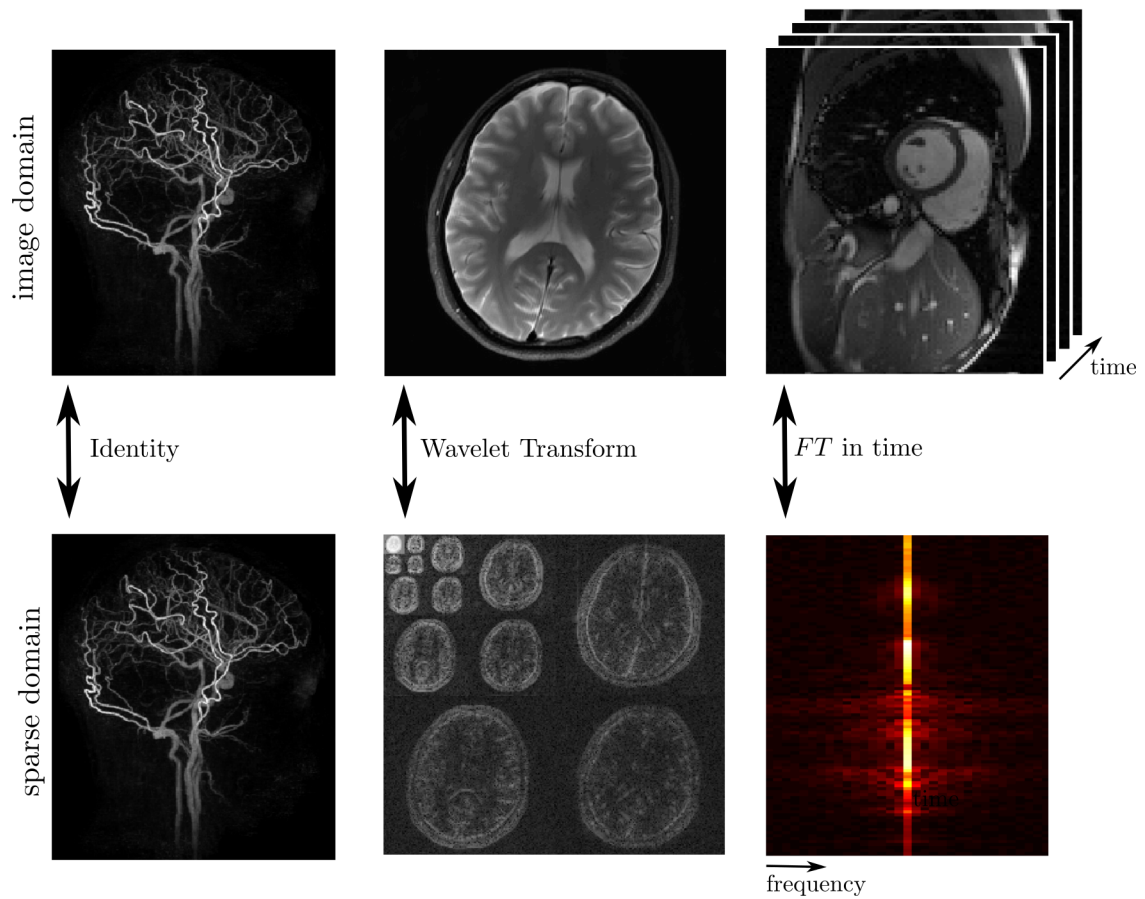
shows three different examples of sparsity that have been used to perform CS reconstructions in MRI. The most prominent example is angiography (shown on the left), where MRI is used to depict blood vessels. Angiograms exhibit a high level of sparsity directly in image space, which make them an ideal candidate for CS reconstructions. Other data (such as the brain image shown in the middle) are not sparse in image space, as can easily be appreciated. An important sparsifying operation is the Wavelet-Transform, which can also be applied to this example. A temporal series of images of a dynamic periodic motion exhibits sparsity in  $xf$ -space ( $f$  = temporal frequency), which can be reached by a conventional Fourier transform in time. A different popular representation called total variation (TV) is given by computing the difference of values of neighbouring pixels [52], which is very sparse for piece-wise constant images. For optimal results, sparsity can be enforced in different domains simultaneously. In general, a compressed sensing algorithm finds a solution to the inverse problem, that is compressible with respect to the sparsifying transform  $\Psi$ .
